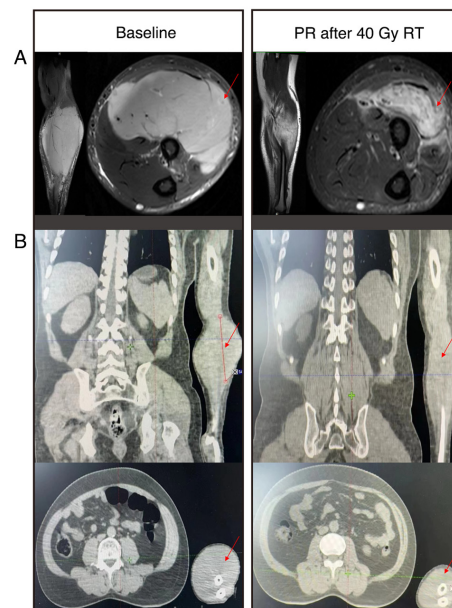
Radiological assessment of tumor response to radiotherapy. (A) Magnetic resonance imaging with contrast and (B) computed tomography of the forearm. The results clearly show a larger tumor mass (red arrow) at baseline (left, March 2024) than after RT (right, April 2024), and indicate PR. PR, partial response; RT, radiotherapy.
